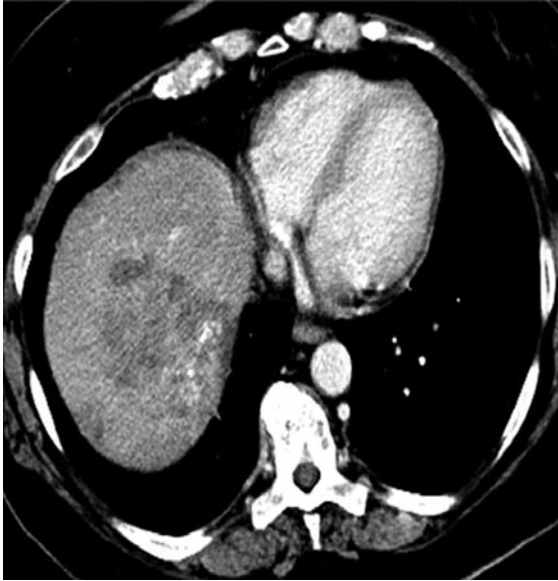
Triple-phase computed tomographic scan prior to DEBIRI treatment.
